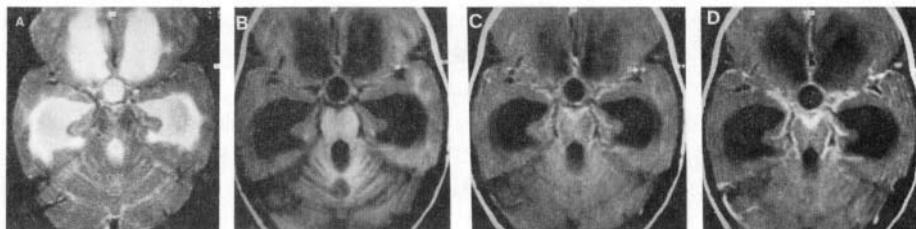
Pyogenic meningitis. T2-weighted axial image (a) at the level of midbrain shows evidence of dilated lateral and third ventricles. T1-weighted axial image (b) shows no other abnormality. MT T1-weighted axial image (c) shows hyperintense thick meninges in the basal cisterns and along the Sylvian fissures and anterior interhemispheric fissure which show enhancement in postcontrast MT T1-weighted image (d).
